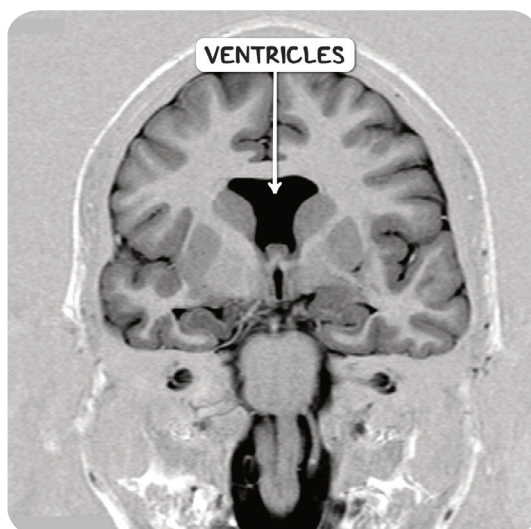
An MRI scan of the head in the coronal plane of an individual with septo-optic dysplasia. The septum pellucidum, which normally separates the two lateral ventricles, is absent.
